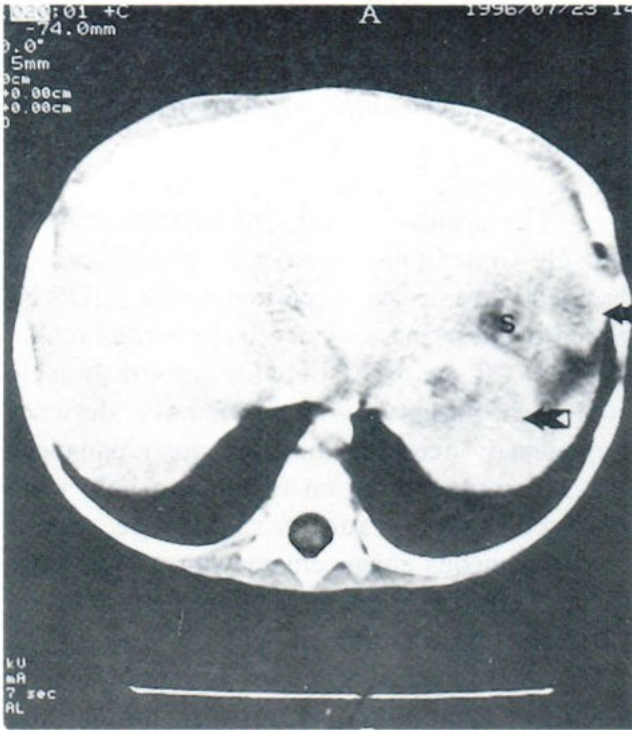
Contrast-enhanced CT scan shows two additional masses (arrows) in left liver lobe. Fundus of stomach (s) is between the masses.
